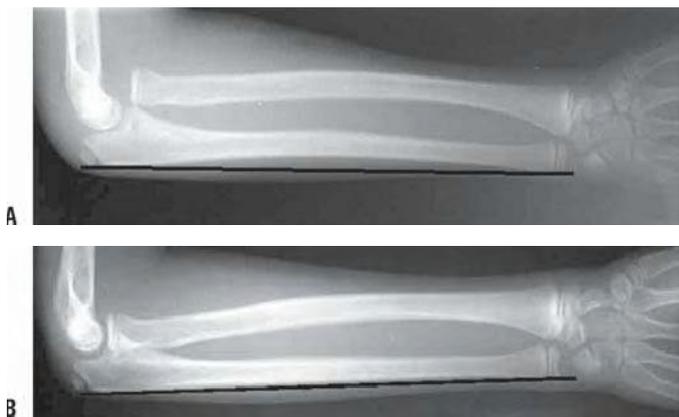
Dislocated radial head with plastic deformation of the ulna. A: A 10-year-old boy presented with elbow and forearm pain after a fall. Radiograph shows complete dislocation of the radiocapitellar joint with plastic deformation of the ulna (note the anterior bow of the ulna demonstrated by a line drawn along its subcutaneous border). B: Contralateral, uninjured arm. Note the straight subcutaneous border.
